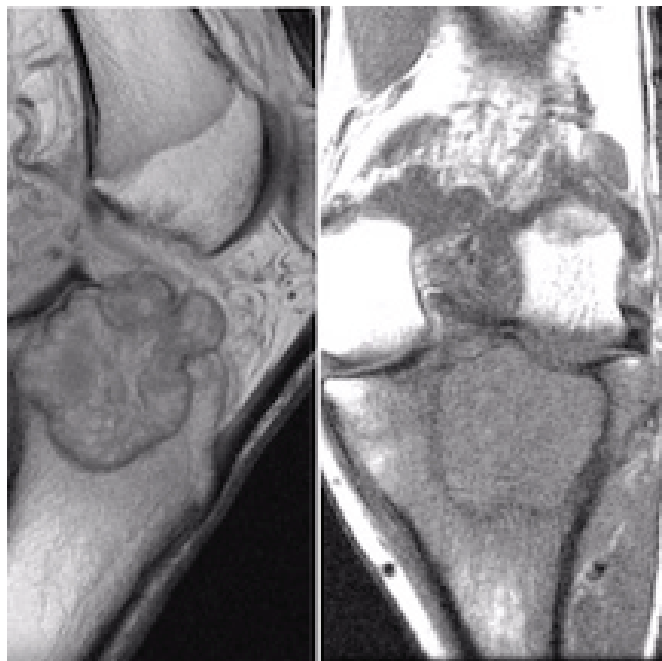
T1 weighted magnetic resonance imaging, sagittal and coronal views showing intermediate signal intensity of the tumour.
